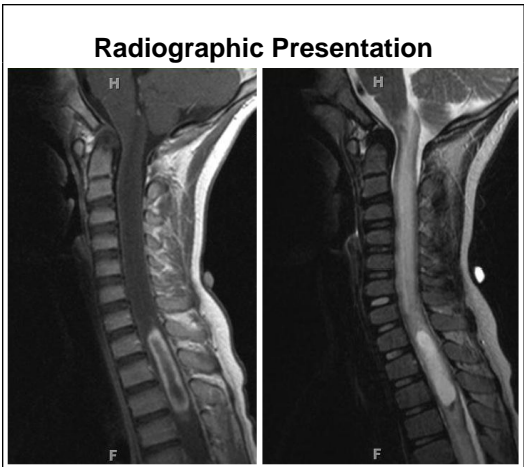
Sagittal T1 and T2-weighted images showing intramedullary spinal cord tumor from T1-T4. Hypointense on T1, Hyperintense on T2, with extensive cord edema.
